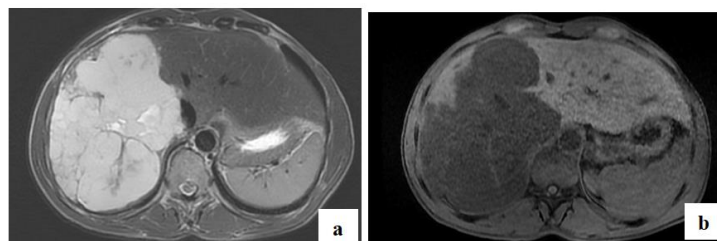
Axial-section T1 and T2 MRI showing the hemangioma in T2 hypersignal (a) and T1 hyposignal (b), septa in T2 hyposignal
